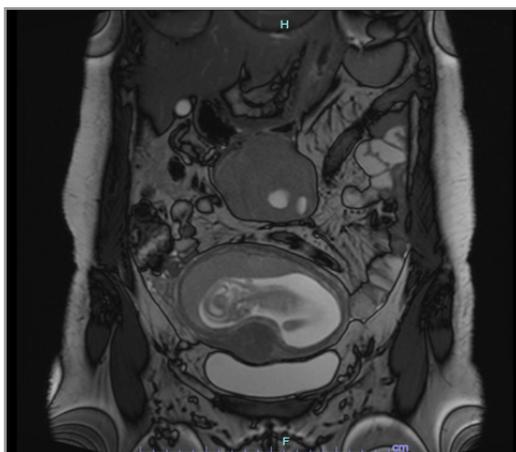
MRI abdomen shows an exophytic mass arising from the greater curvature of the stomach measuring 6.2 x 8.7 x 7.7cm
